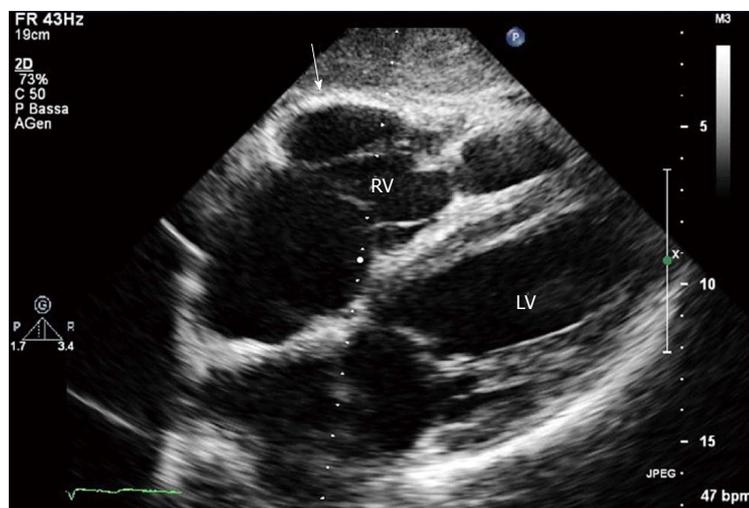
Two-dimensional echocardiogram, 4 chamber subcostal view, end diastolic frame, in an arrhythmogenic right ventricular cardiomyopathy patient. RV wall aneurysm at subtricuspid basal level is evident (arrow). LV: Left ventricle; RV: Right ventricle.
